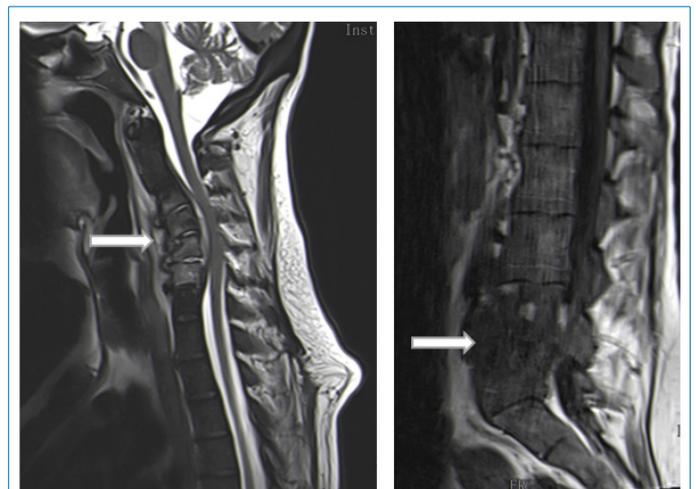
Magnetic resonance imaging of C3-C6 spondylodiscitis, spinal cord compression, and L4-L5 spondylodiscitis (white arrow).
